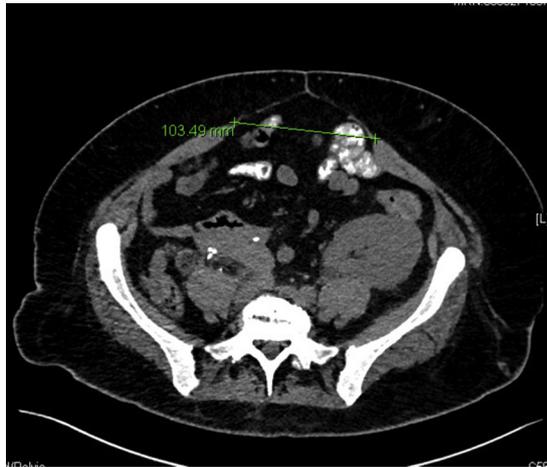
Preoperative CT scan of ventral hernia. Preoperative CT scan of a representative patient in our series showing a large ventral hernia measuring 10 cm in transverse dimension. The bilateral rectus complexes have migrated laterally from the midline with retraction of the oblique musculature visible. (Color version of this figure is available online.)
